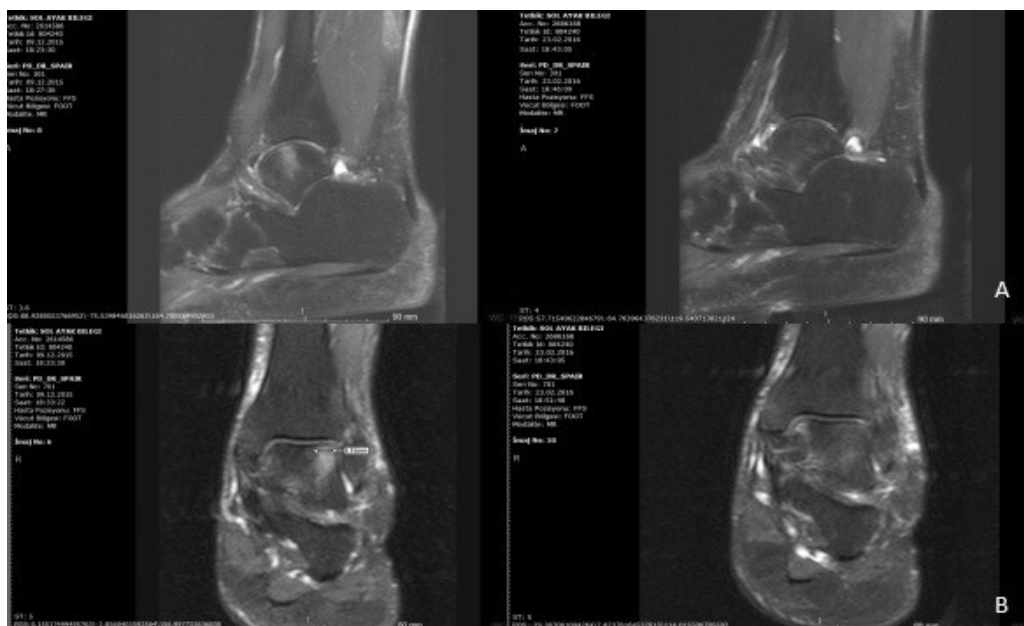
Comparison of preoperative and 3-month postoperative MRI image of the osteochondral talar defect
